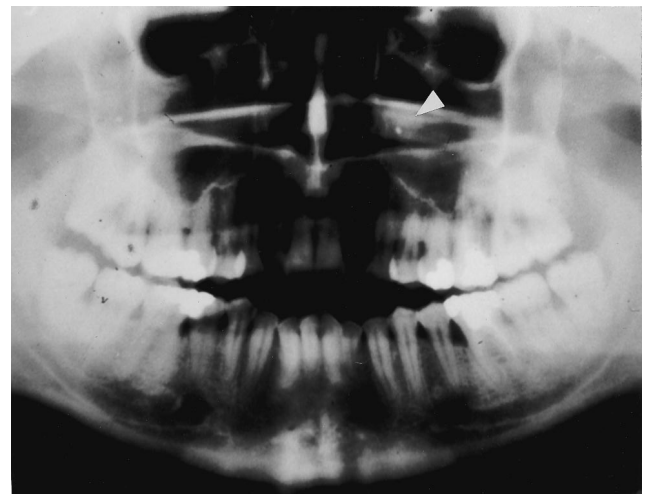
Panoramic radiograph (left side) showing a small radiopacity in the maxillary sinus representing root canal material that has been transported close to the natural foramen of the sinus over the years (arrowhead).
